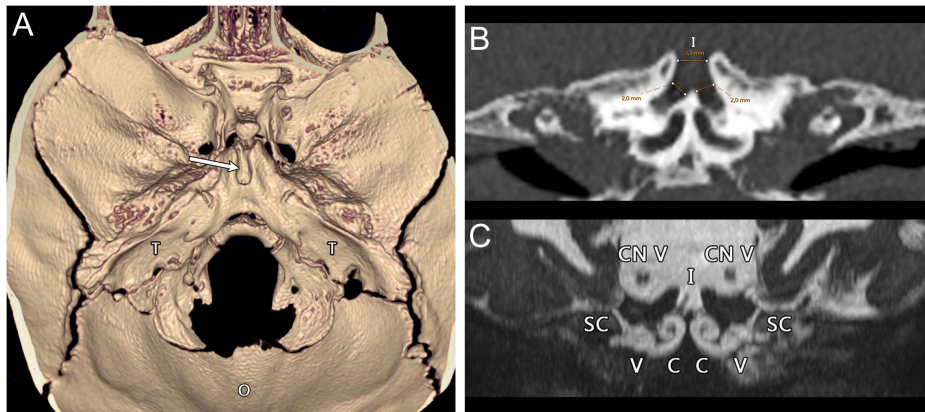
(A) Top view of the 3D surface rendering of temporal bone CT. (B) Coronal oblique view of temporal bone CT passing through the IAC level. (C) Coronal oblique MIP view passing through the IAC level of MRI. Abbreviations: Arrow, single internal acoustic canal in the midline; C, cochlea; CN V, cranial nerve V (trigeminal nerve); I, internal acoustic canal; O, occipital bone; SC, semicircular canal; T, temporal bone; V, vestibule.
